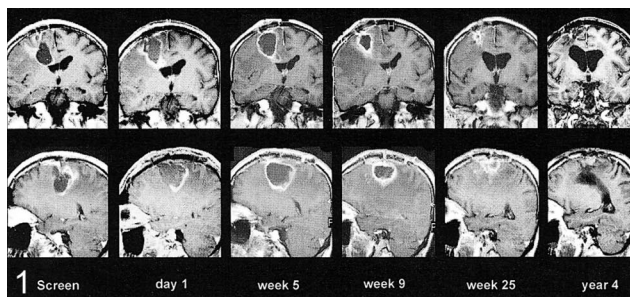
Flare enhancement. MR images obtained preoperatively and on day 1; weeks 5, 9, and 25; and year 4 postoperatively show development of a strong nodular flare very early with massive edema around the precentral resection cavity. Later images show progressive shrinking, leaving scarce residual evidence after 1 year (enhanced T1-weighted coronal and sagittal MR images, patient 1).
